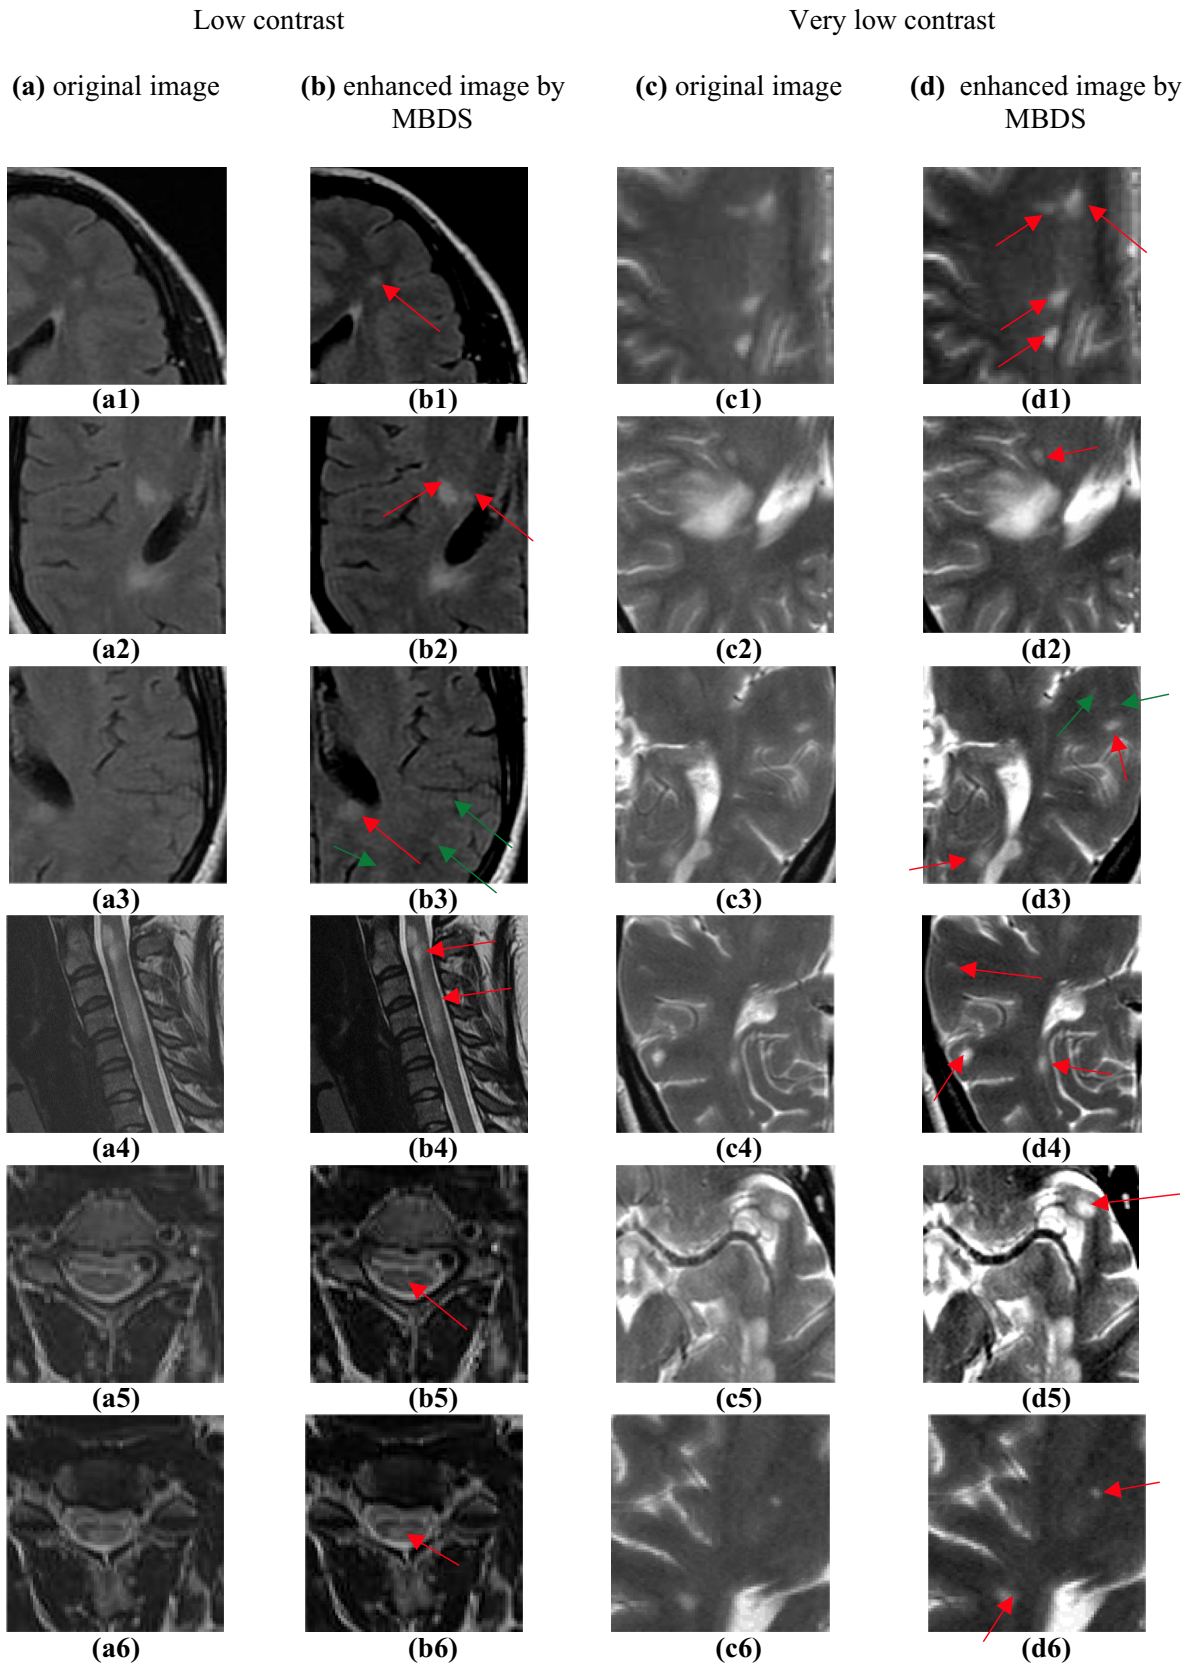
Original and enhanced images with the proposed method MBDS; a1–a6 original low contrast MRI images and b1–b6 enhanced images by MBDS with green and red arrows representing
